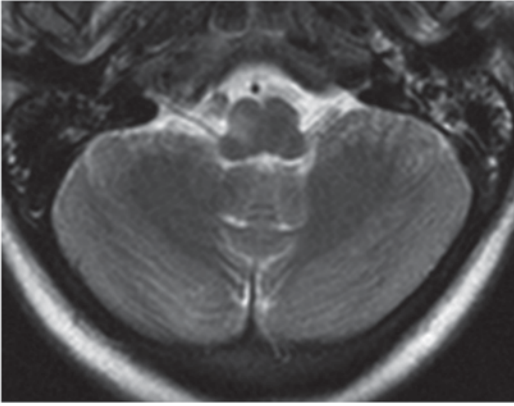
Diffusion-weighted MRI of medulla showing acute infarct in lateral medulla (bright signal) in a 45-year-old woman with history of hypercholesterolemia and smoking. (Courtesy of Dr. Blaine Hart)
